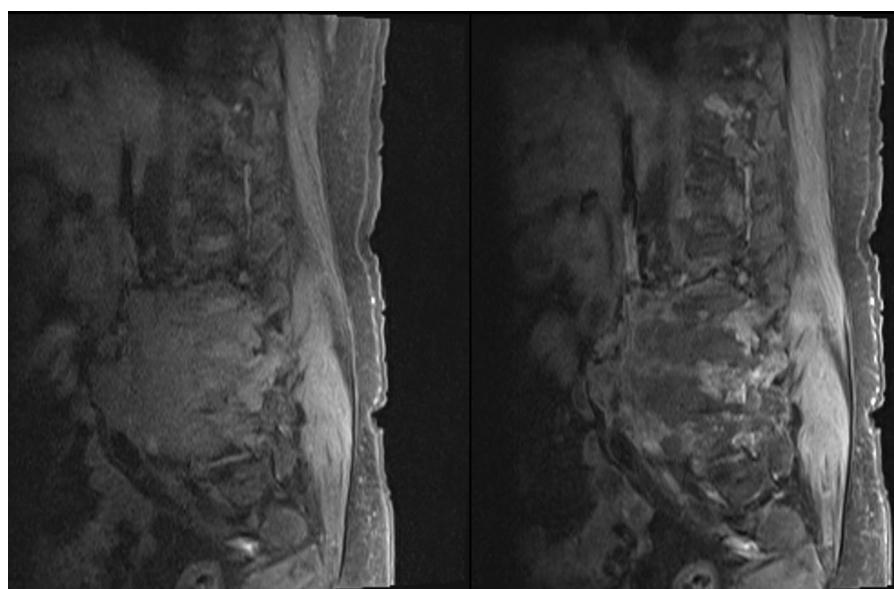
Sagittal non-contrast fat-saturated T1-weighted (Left) and contrast-enhanced fat-saturated T1-weighted (Right) MR images show heterogeneous lesion with peripheral enhancement in the right psoas muscle associated with bone involvement of the lumbar vertebrae.
